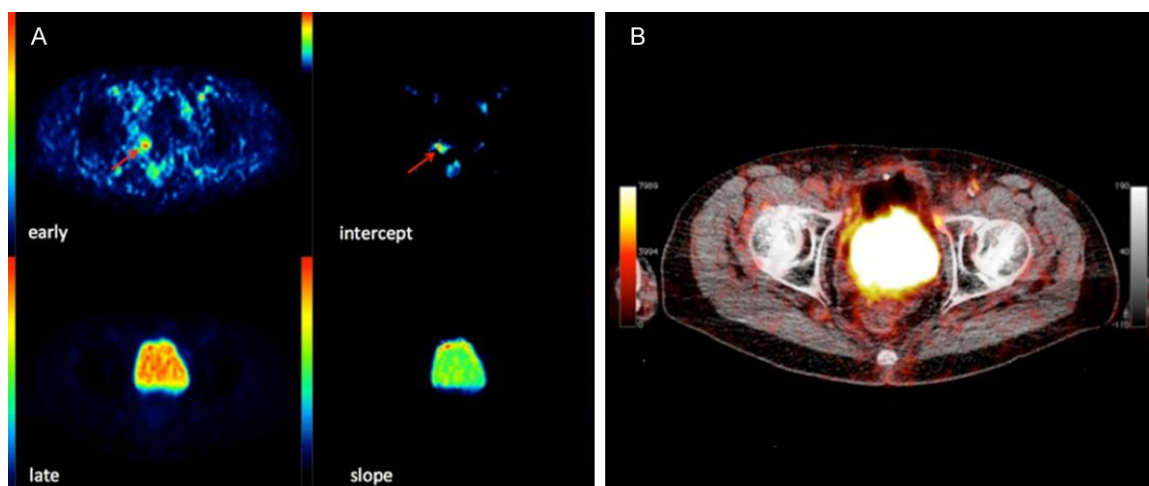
⁶⁸Ga-PSMA-11 PET/CT of a 71-year-old patient with biochemical recurrence of PC (PSA at 0.18 ng/ml). A. Shows increased ⁶⁸Ga-PSMA-11 accumulation in the prostate fossa in the early dynamic image 6 min p.i. (arrow in the upper left image, ‘early’), which is not observed in the late static image 60 min p.i., since it is ‘masked’ by the overlying bladder activity (lower left image, ‘late’). High signal in the area of the local recurrence in the intercept (arrow in the upper right image, ‘intercept’) but not in the slope (lower right image, ‘slope’) parametric Patlak-based image. B. Exhibits no pathological ⁶⁸Ga-PSMA-11 accumulation in the fused PET/CT image at 60 min p.i.
